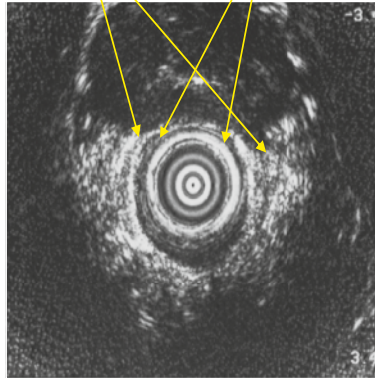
An example of the ultrasound appearance of an internal anal sphincter (IAS) injury following anal surgery
